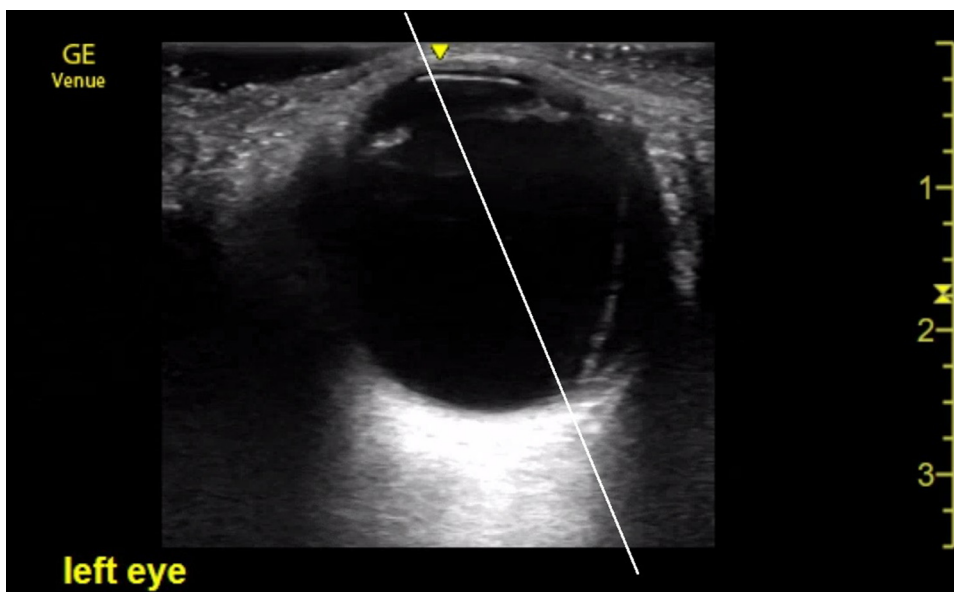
Ultrasound of left eye temporal retinal detachment sparing the pupillary midline (white line), with macula intact.
